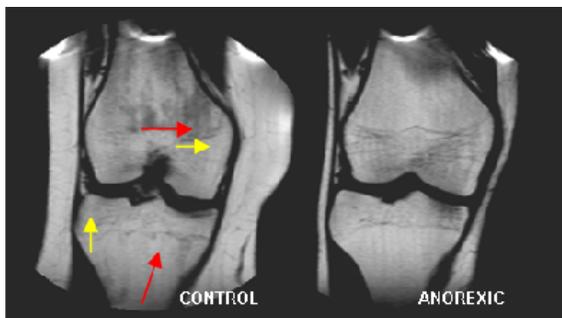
T1-weighted images (TR/TE=350/17 msec) from an anorexic and age-matched control showing lower signal intensity in red marrow in control. Red and yellow arrows indicate regions chosen for ROIs representing red and yellow marrow respectively.
